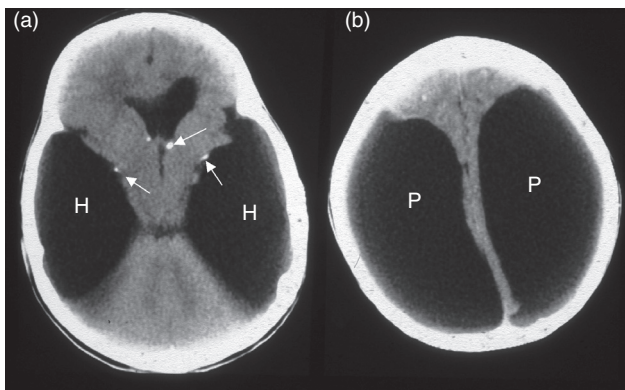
Congenital toxoplasmosis: (a,b) CT with hydrocephalus (H), porencephaly (P), and calcifications (arrows).
